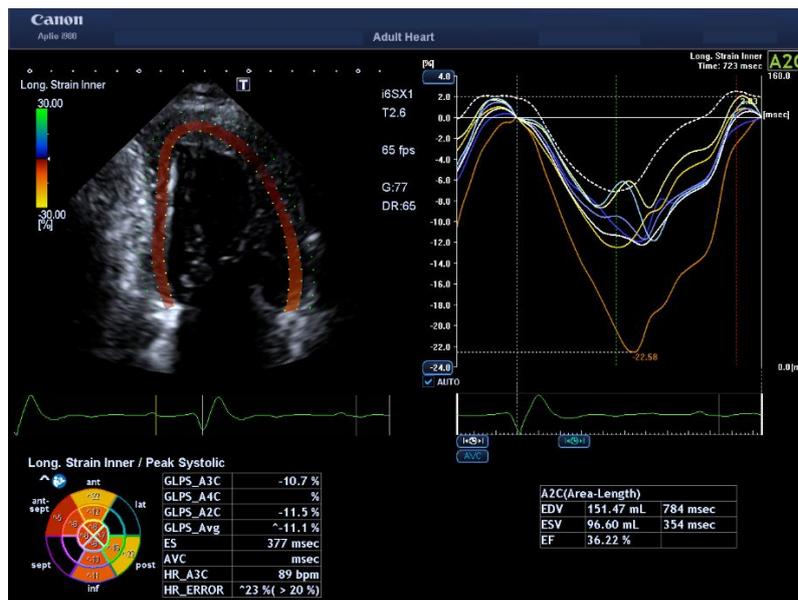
Global longitudinal strain in the apical 2 chamber view in a patient with impaired LV function due to ischaemic heart disease
